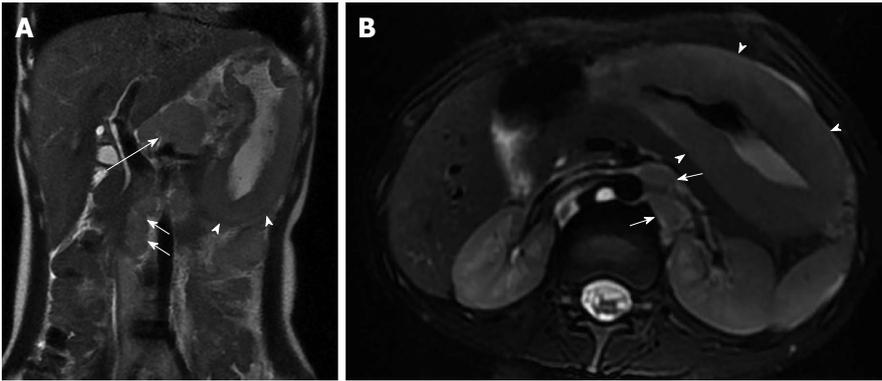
Non-Hodgkin lymphoma of the stomach. A: Coronal T2-weighted single shot fast spin echo (SSFSE) and (B) axial fat-suppressed T2-weighted SSFSE images. There is marked, diffuse, asymmetric gastric wall thickening with smooth outlines, predominantly involving the gastric body and antrum, associated with mildly increased heterogeneous T2 signal intensity (arrowheads, A and B), large conglomerate nodal mass at the gastrohepatic ligament (long arrow, A), and multiple enlarged retroperitoneal lymph nodes (short arrows A and B). Constellation of findings is diagnostic of non-Hodgkin gastric lymphoma with diffuse abdominal lymphadenopathy.
